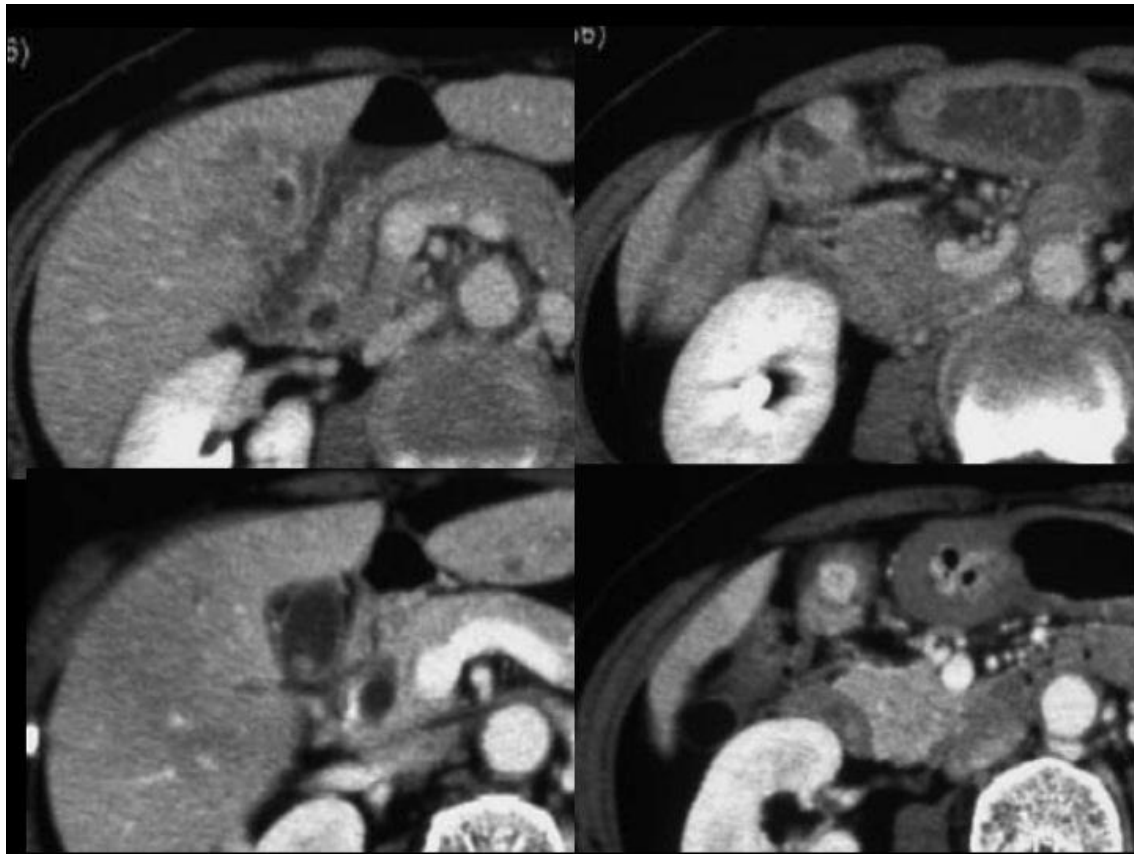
Abdominal CT findings. Primary tumor is reduced after two cycles of combination chemotherapy.
